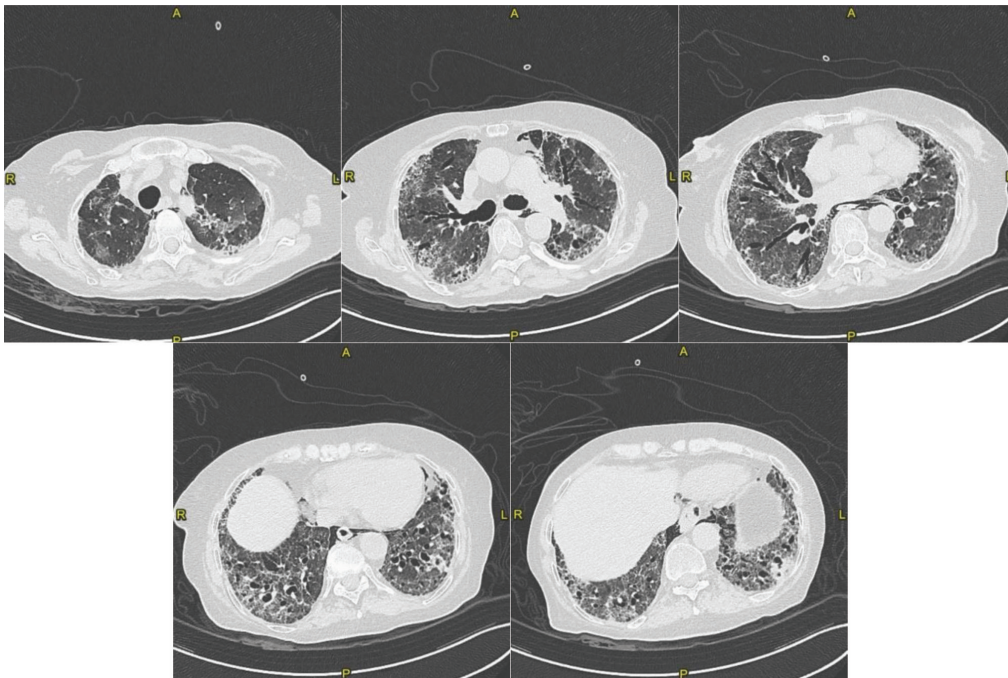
CT scan at 2nd hospitalization (August 2020): The parenchymal fibrosing pattern is globally worsened (extension score 75%), showing new ground glass areas (superior lobes) and traction bronchiectasis. New parenchymal peribronchial consolidation in the inferior left lobe, suggestive of infection (maybe of fungal nature). Significant decrease of the extension of the known pneumomediastinum.
